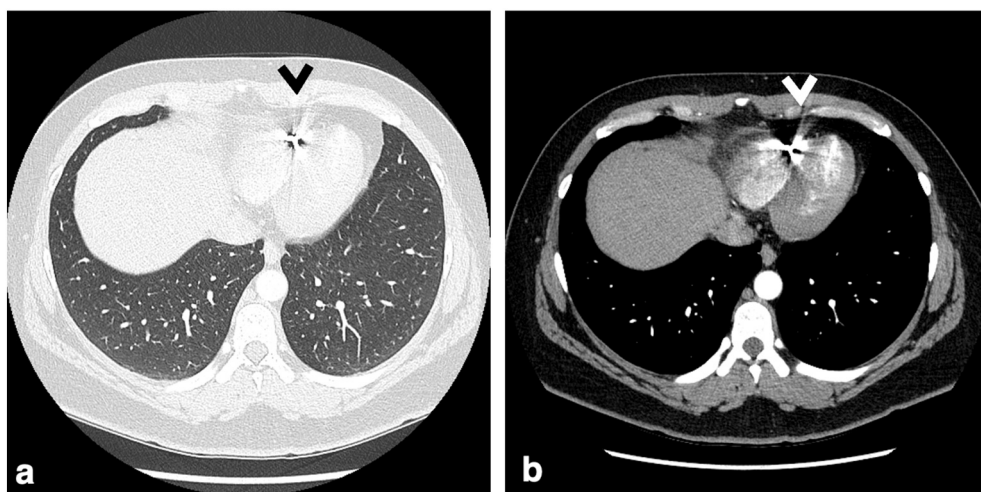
Axial CT angiography images of the thorax in lung (a) and soft tissue (b) windows showed a 5 mm foreign body in the right ventricle (arrowhead “<”). The remainder of the scan was unremarkable and there was no pneumothorax, hemothorax, hemopericardium, vascular injury, soft tissue or osseous injury, or pulmonary injury to suggest intrathoracic penetration.
